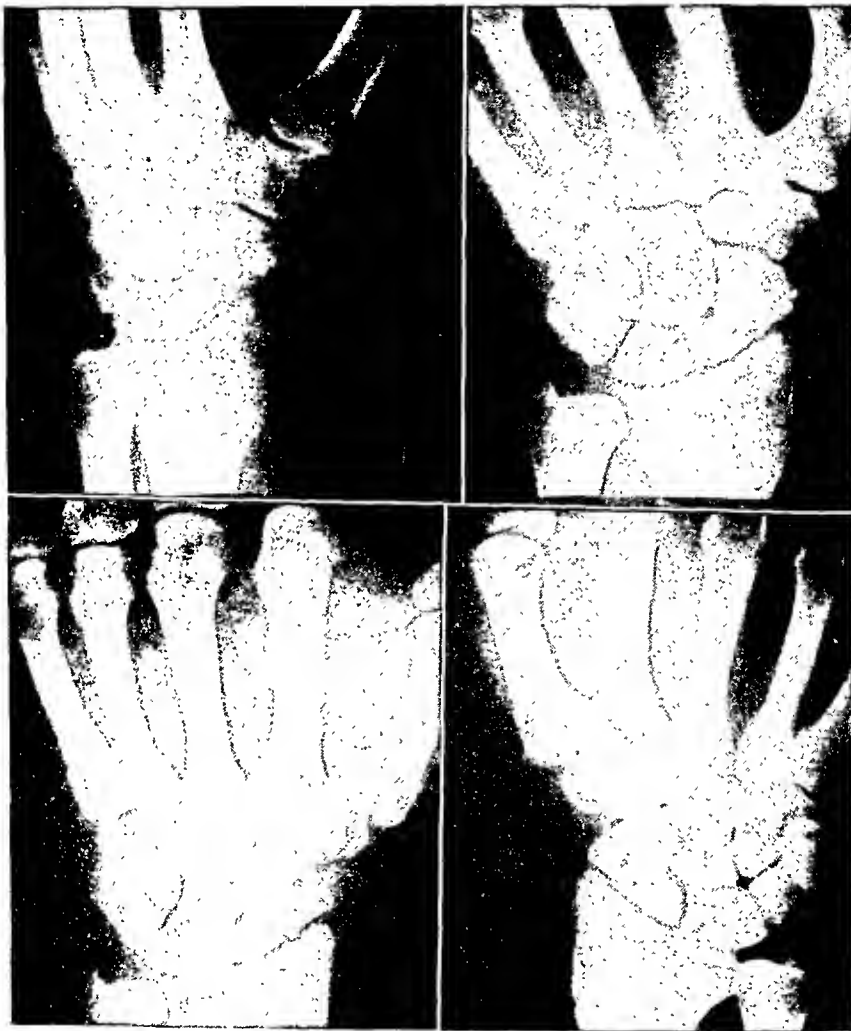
Case 6: Old, previously undiagnosed fracture of the carpal scaphoid. "Sprain" of wrist 30 years ago. No previous roentgen study.
